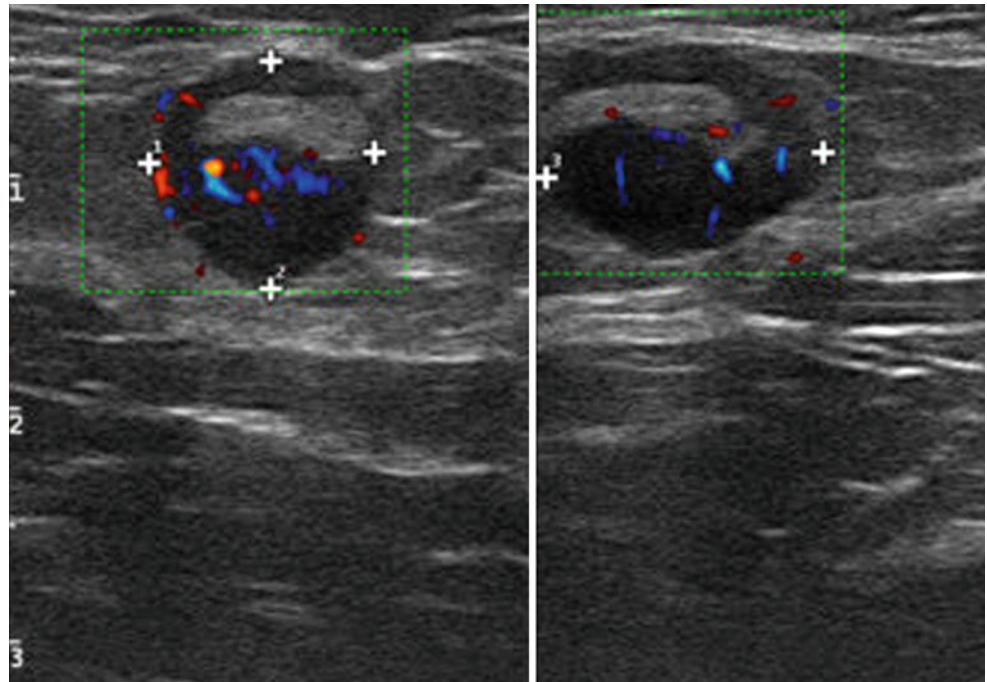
Metastatic lymph node. Directional power Doppler image. Asymmetrical broadening of the parenchyma, accompanied by a hyperperfusion selectively in this area
